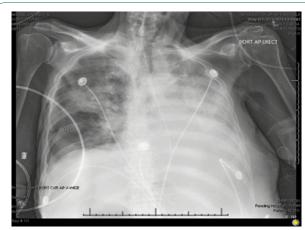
Chest X-ray showing large opacification in the left hemithorax with corresponding leftward mediastinal shift.
